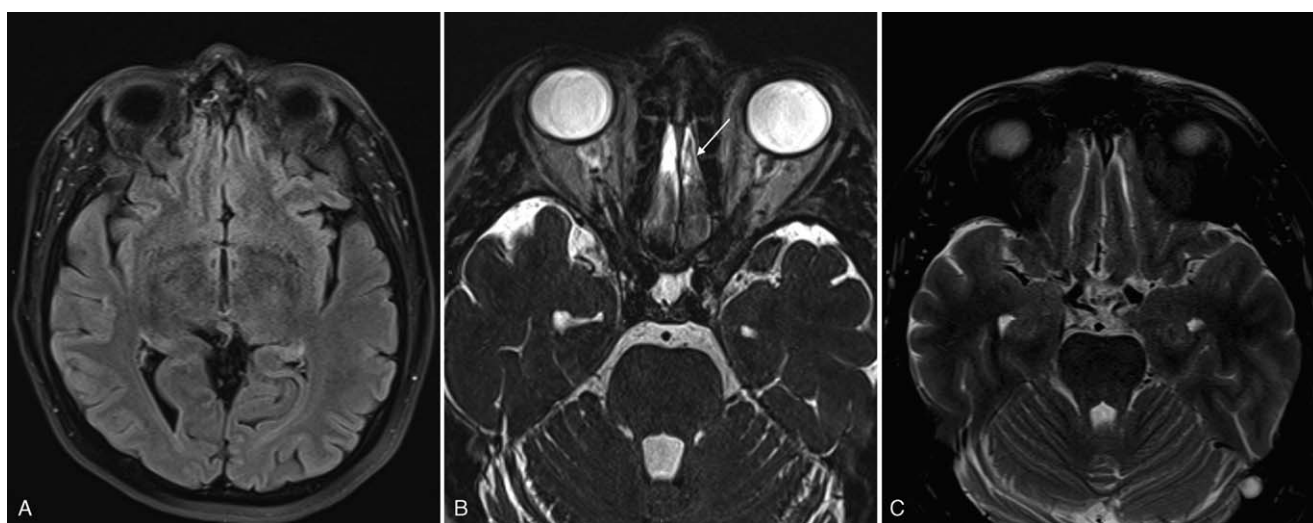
A–C, Axial 3T MRI (A, FLAIR, B, high-resolution thin section T2, C, axial T2 with fat saturation) with FLAIR and T2 hyperintensity in olfactory bulbs and tracts (white arrows).
